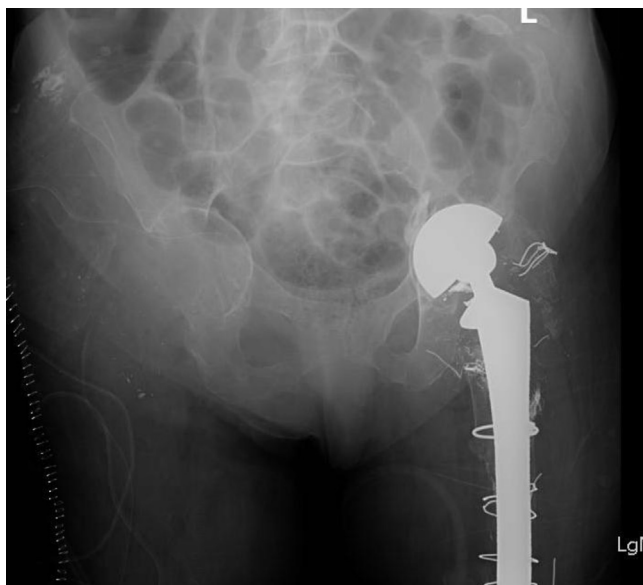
Post-operative AP radiograph following right hip disarticulation.
